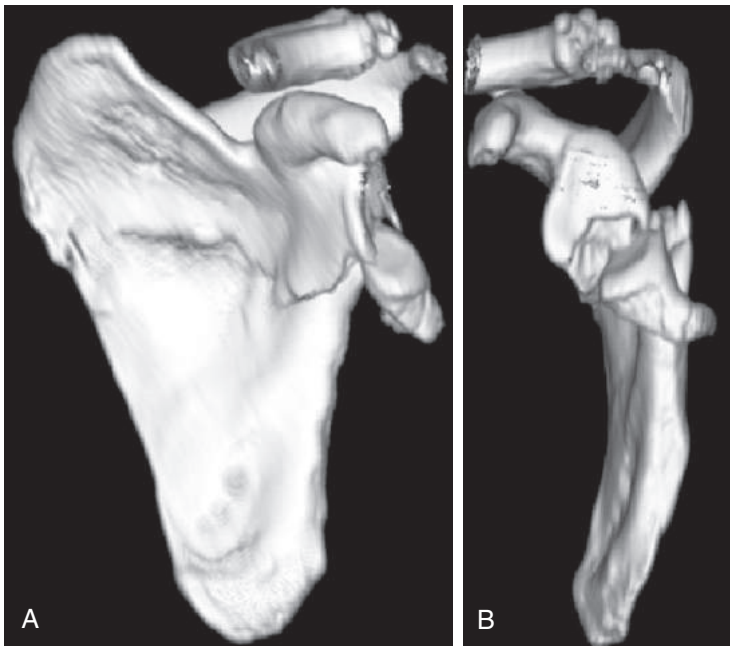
A–B This shows three-dimensional CT views of the type Vc injury sustained by the bicyclist. injury sustained by the bicyclist.
